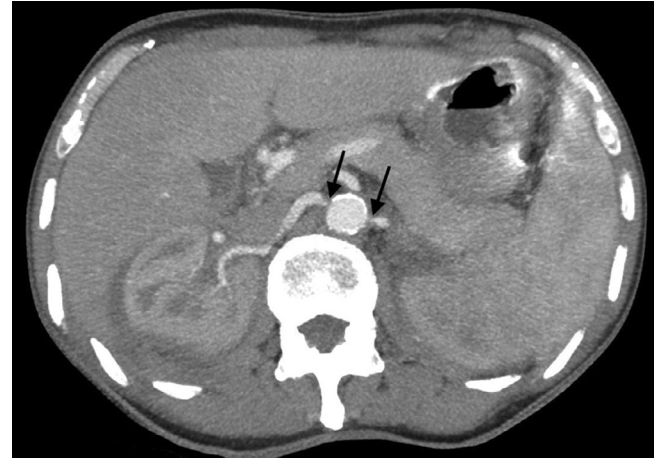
A 53-year-old male patient with Erdheim Chester disease. Abdominal CT scan after contrast injection in axial view with maximum intensity projection (MIP) reconstruction showing bilateral renal artery ostial stenosis. (black arrow).
